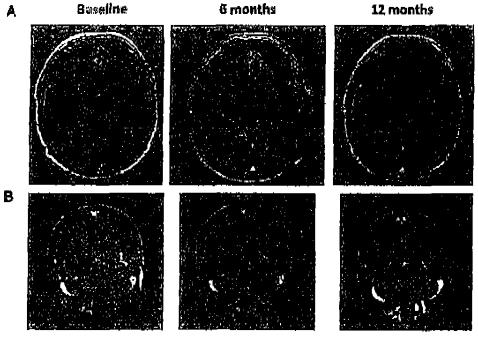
Exemplary TI weighted magnetic resonance imaging (MRL) images with gadolinium from two Tumour Treatment Fields (TTF) palients wild partial response to therapy. (A) A 48 years old main with prior grade II astropytoms, which transformed to gliobinstoms (based on tissue bloosy. The subject progressed 7 months after receiving chemoradiotherapy, and subsequently responded to TTP therapy (partial response at 12 months) and remained stable for an additional 364 months on TTP. (B) A 55 years old mule with primary glioblastoma who recurred for the third time after receiving absencratiotherapy, adjuvant temprolomide (2 cycles), bevarizumab with trinotegun (3 months) and arieticib with sorefault (one cycle). The subject had a partial response to TFF thatapy after 4 months of treatment and remained stable for an additional B ruopthe while on TTP.
